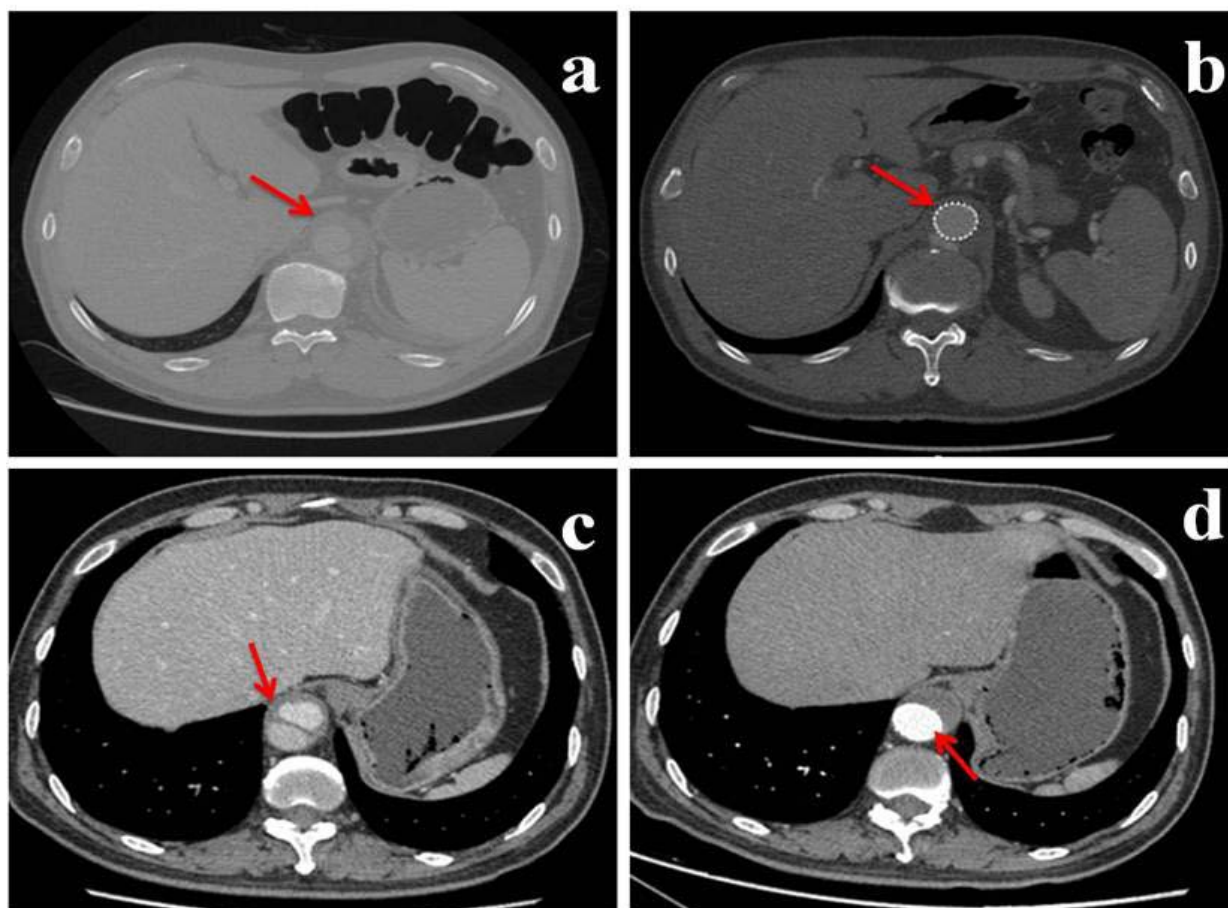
CT scan showed the arterial dissection thrombosis 1 to 4 weeks after operation (a: Dissecting aneurysm of abdominal aorta before surgery; b: Post-surgery, CT scan showed partial thrombosis; c: Dissecting aneurysm of abdominal aorta before surgery of another case; d: Post-surgery, CT scan showed complete thrombosis)
